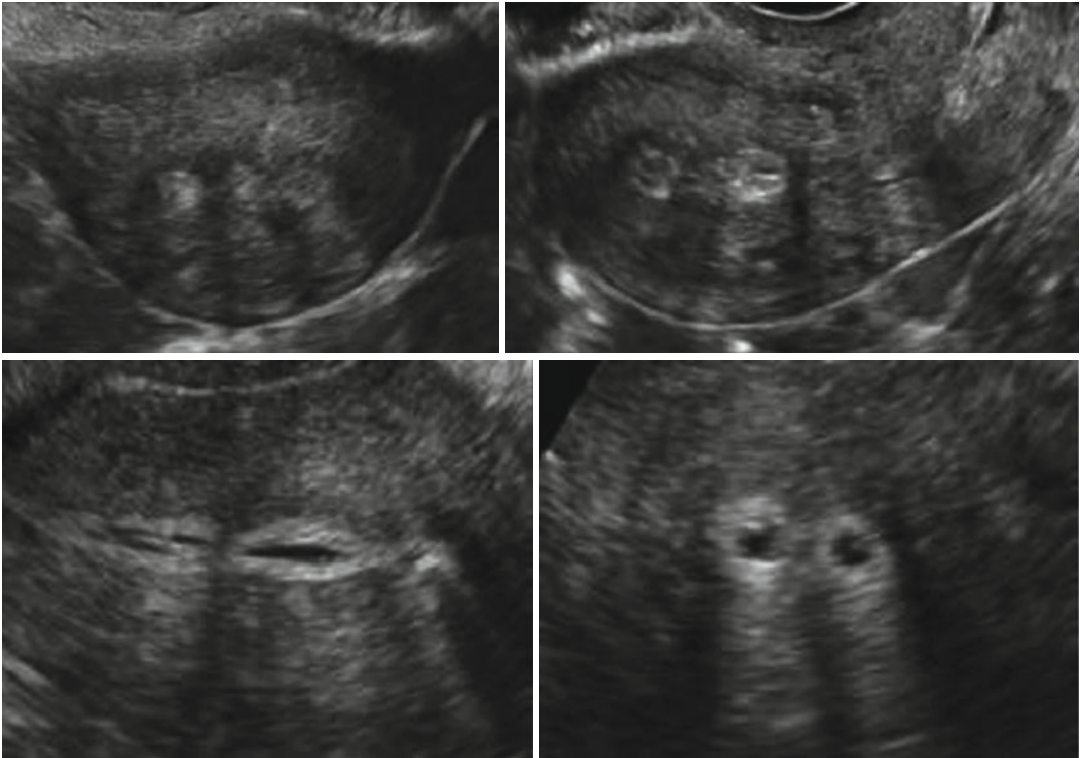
Ultrasound and saline infusion revealing filling defects in a patient with AS
